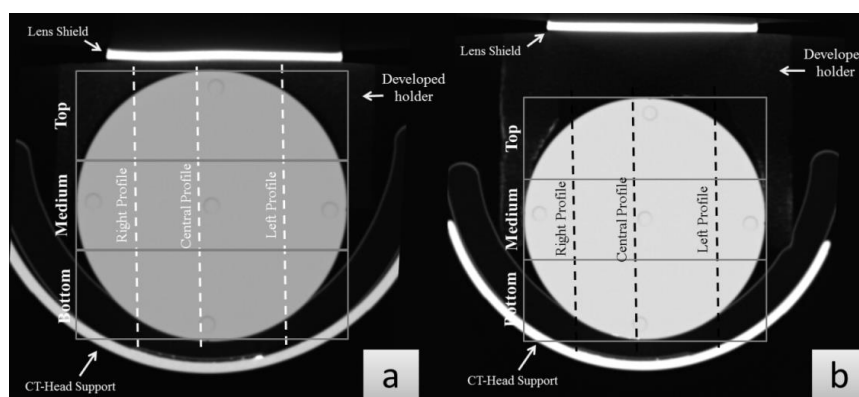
Defined areas and extracted profiles in the CT images for image quality assessment. a) “Contact” setup. b) “Distant shield” setup.
